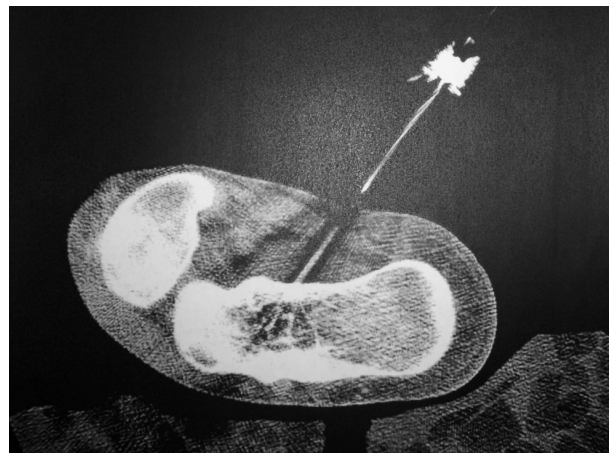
Radiofrequency ablation needle under computed tomography guidance.
